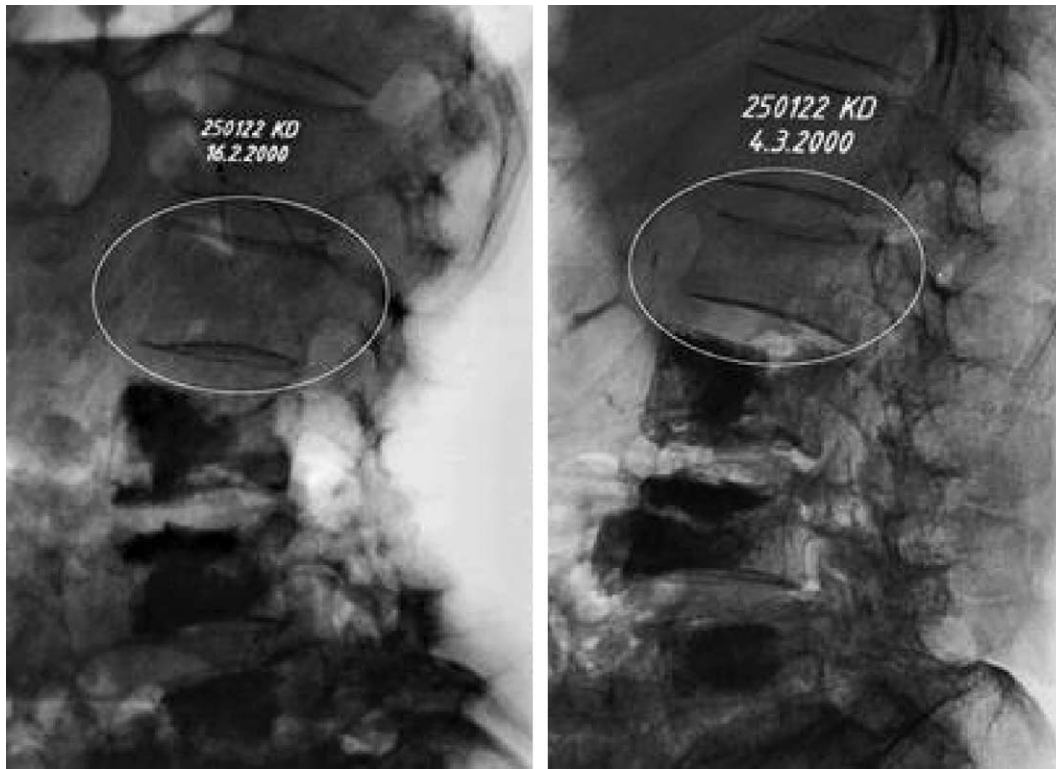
The radiograph on the left was taken immediately after vertebroplasty and the radiograph on the right 2 weeks later. This second radiograph shows a compression vertebral fracture adjacent to the cemented vertebra from [37], with permission.
